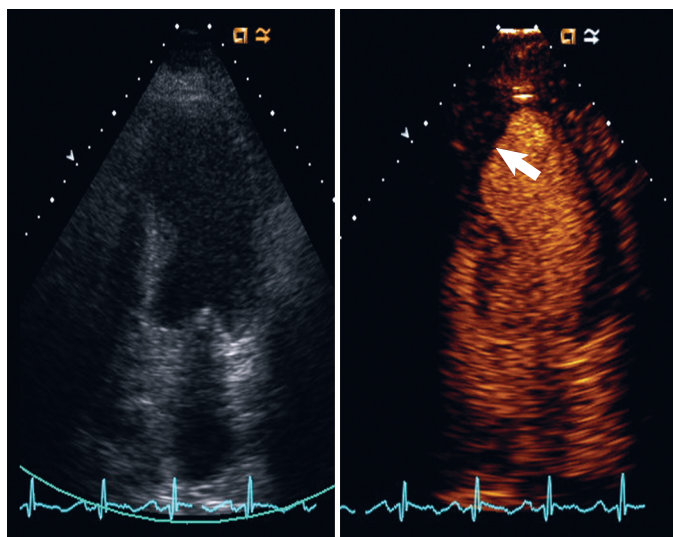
Unenhanced (left panel) and contrast-enhanced (right panel) apical four-chamber systolic images. In the unenhanced image it is impossible to define the endocardium, whereas with contrast enhancement the endocardium is clearly delineated and the straight margin characteristic of a sessile apical thrombus (arrow) is appreciated.
